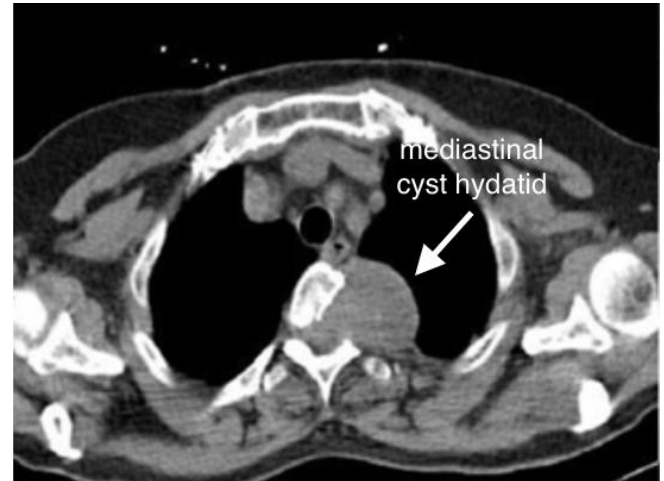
Vertebral invasion thorax Computed Tomography image
